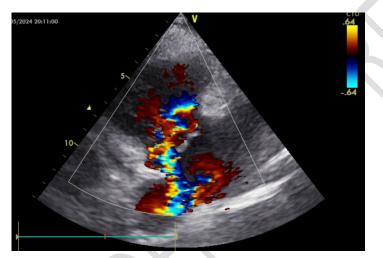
Color Doppler echocardiographydemonstratedseveretricuspidregurgitation
